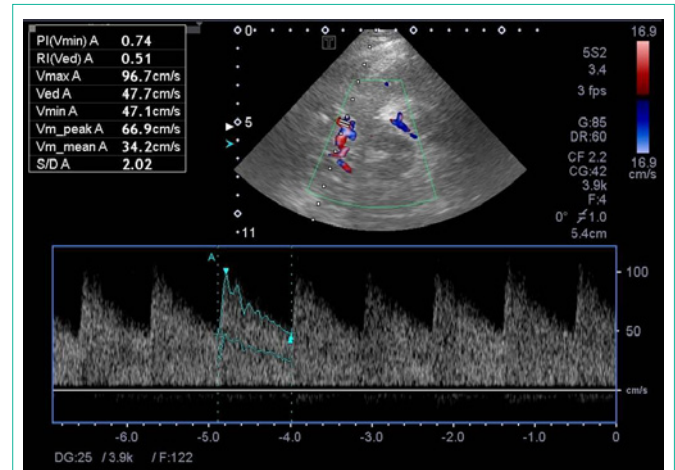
Color and spectral Doppler. Insonation of middle cerebral artery by transtemporal window.
